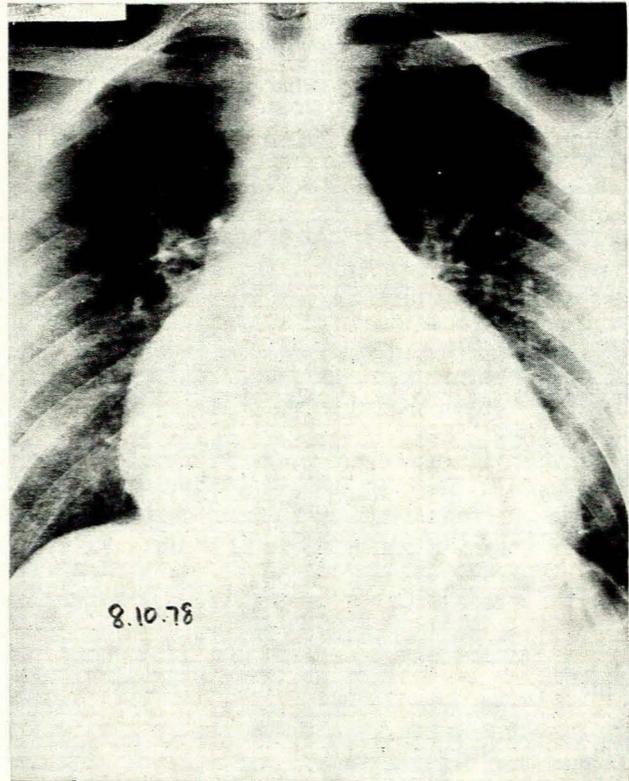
Chest radiograph showing pancardiomegaly, dilatation of main pulmonary artery segment and marked upper lobe pulmonary venous congestion.
